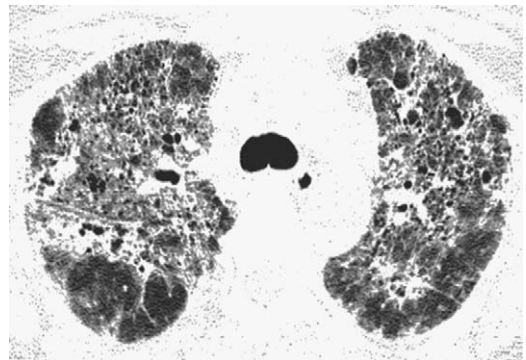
Sarcoidosis (late, fibrotic stage). HRCT shows fibrosis and honeycombing in the upper lungs on both sides.
